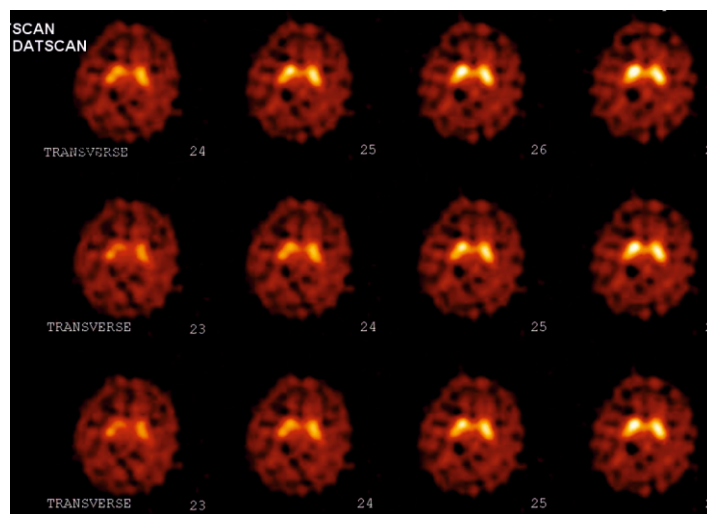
Patient №2 (normal FP-CIT-SPECT)– ET
